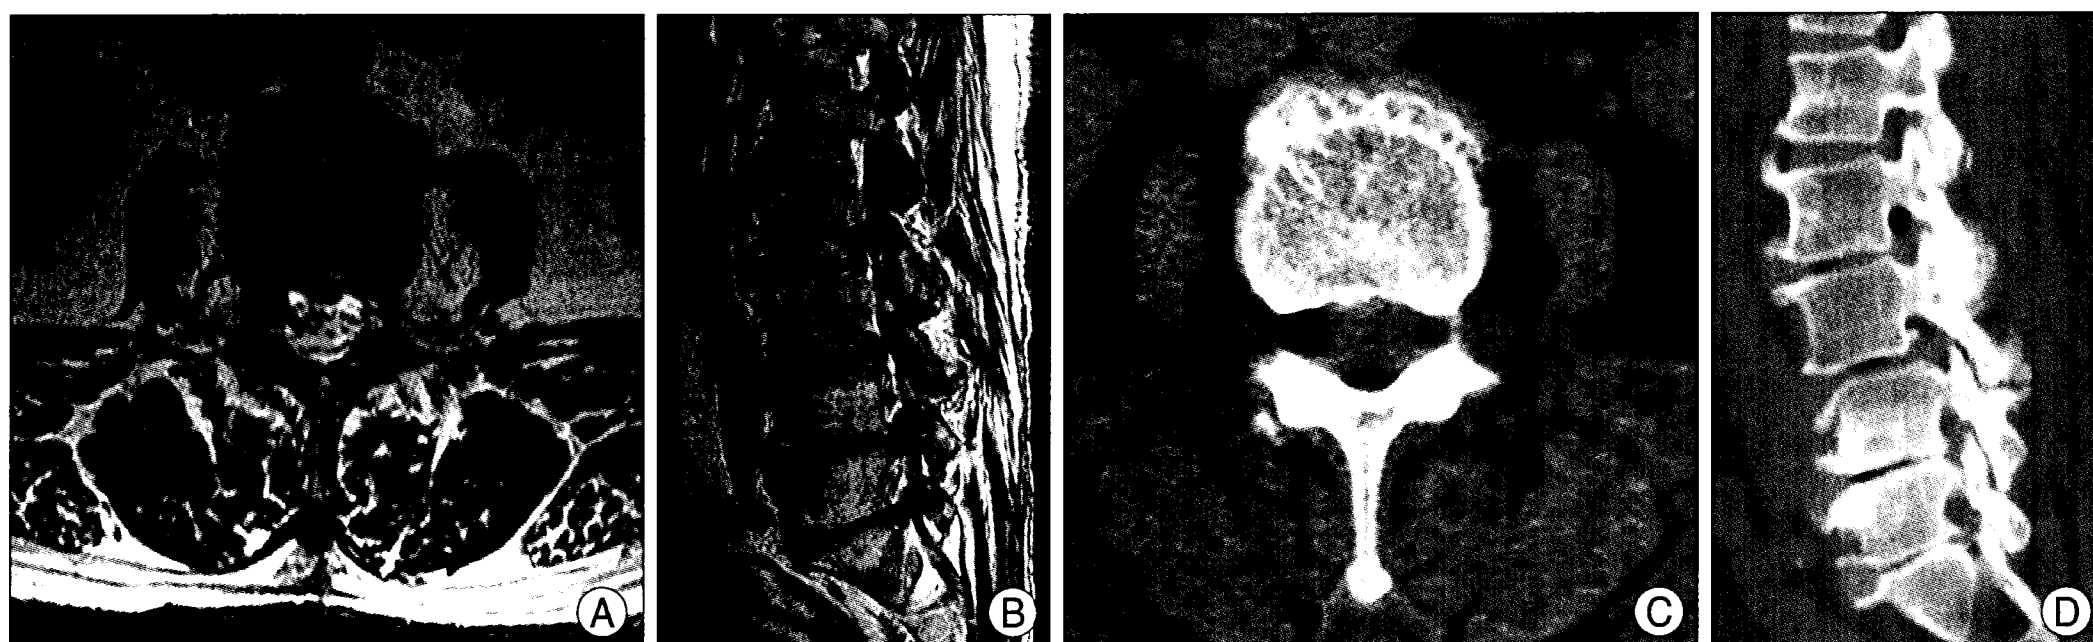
Magnetic resonance images (MRI) (A and B) and computed tomography (CT) scan (C and D) showing a gas pseudocyst that is compressing the root at the right L2-3 foramen. T2-weighted sagittal MRI (B) and sagittal reconstruction image of CT scan (D) show that the gas pseudocyst is connected to L2-3 intervertebral disc, which contained intradiscal gas. Therefore, the gas pseudocyst in the foramen was assumed to originate from the gas in the L2-3 intervertebral disc.
